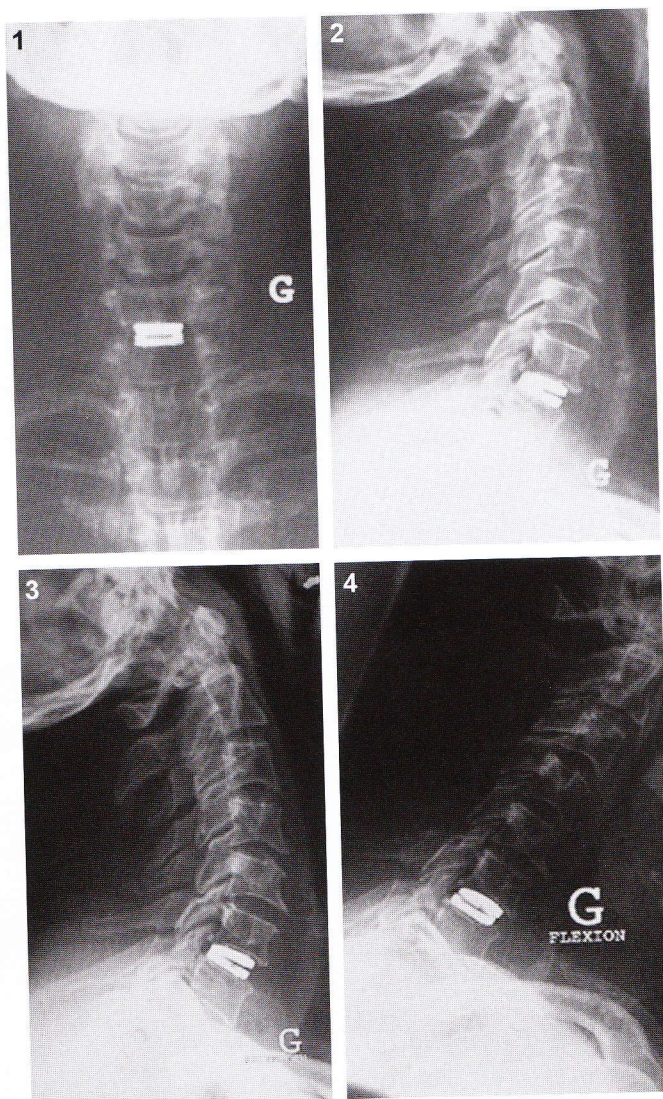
Postoperative radiography of the same patient showing the intact lordosis and the operated level mobility: (1) facing; (2) profile in neutral position; (3) profile in extension; (4) profile in flexion
